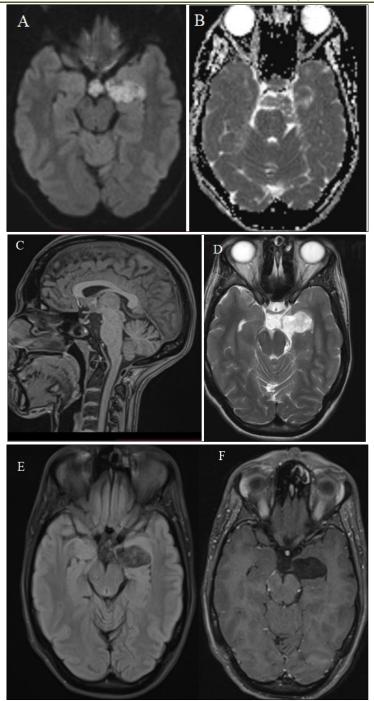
MRI features of a left temporal epidermoid cyst involving the mesial temporal lobe and extending toward the cerebellopontine angle
